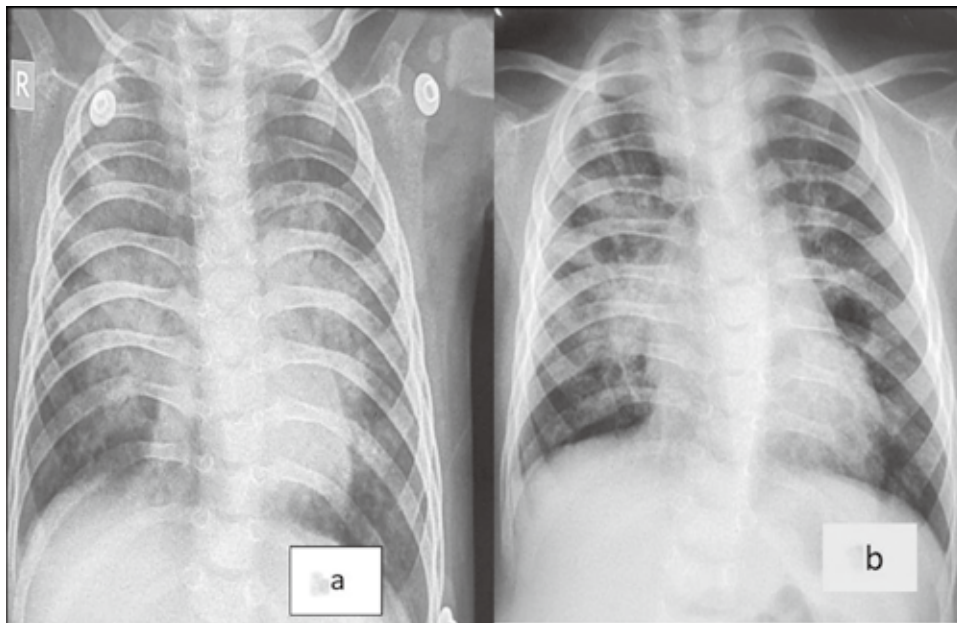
Chest radiograph frontal view (a) showing bilateral hilar and parahilar non-homogeneous opacities with air bronchogram. (b) in same child remarkable resolution of opacities especially on left side after 2 months of treatment with oral steroids.
